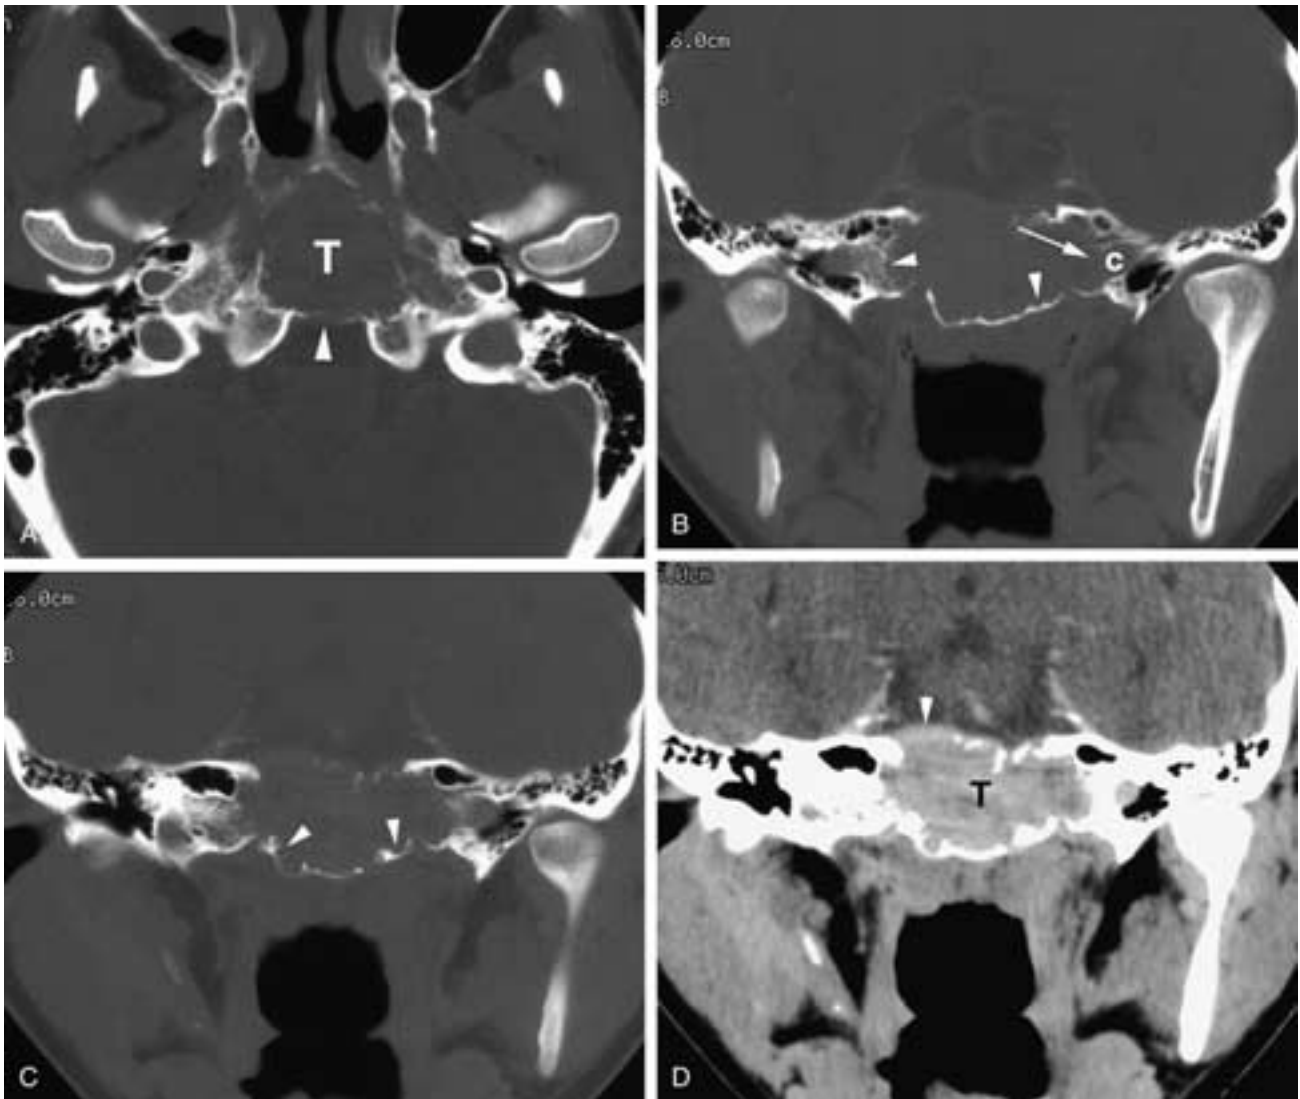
Chondromyxoid fibroma. A, Axial CT bone algorithm shows a tumor (*T*) bulging slightly through the posterior plate of the clivus (*arrowhead*). B, Coronal bone algorithm shows slight curvilinear scallops (*arrowheads*) along the margin. The bony wall (*arrow*) of the carotid canal (*C*) is eroded. C, Coronal bone algorithm shows slight scalloped areas (*arrowheads*). D, Coronal postcontrast soft-tissue window shows the tumor (*T*) bulging (*arrowhead*) into the posterior fossa.
